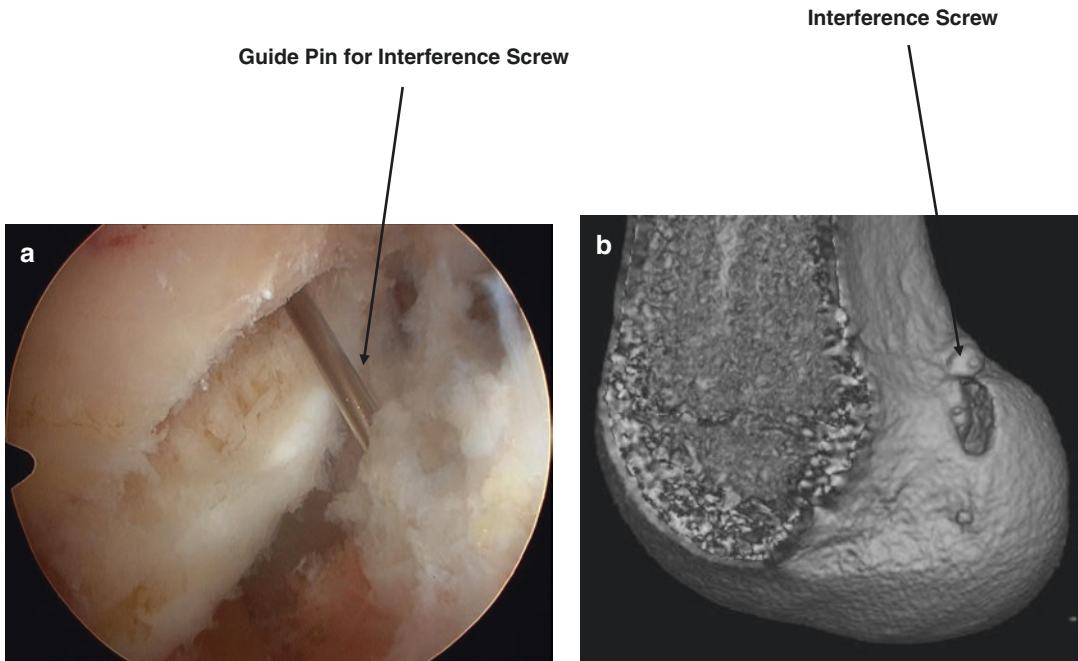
Created rectangular tunnel aperture inside the femoral attachment area. (a) Arthroscopic view through the anteromedial portal. (b) 3-D CT view
